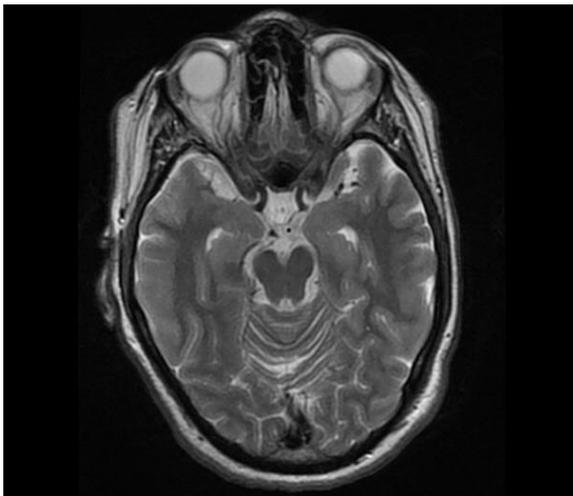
MRI Axial section of the patient showing hyperintense lesions.
